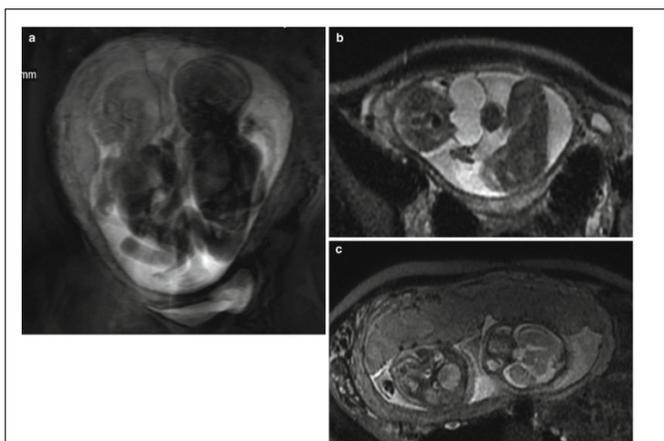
Magnetic resonance imaging showing multiple pregnancy.
